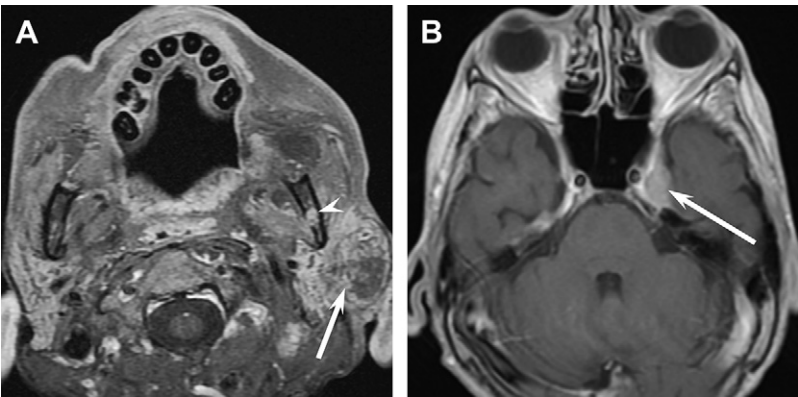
MRI for perineural spread. (A) Axial contrast-enhanced T1-weighted image shows a large enhancing left parotid mass (*arrow*) with abnormal enhancement in the mandibular foramen (*arrowhead*) related to perineural spread along the auriculotemporal nerve to the mandibular nerve. (B) More superior image reveals abnormal enhancement in left Meckel cave (*arrow*) from perineural spread of the parotid tumor intracranially.
